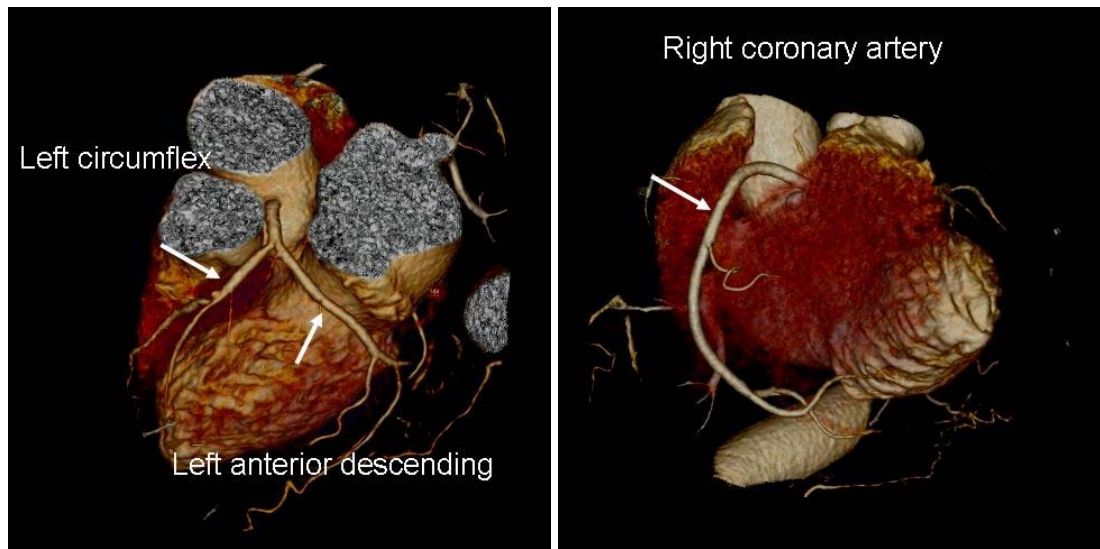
3D CT images of the heart present the left coronary artery and their side branches (left image), and the right coronary artery (right image).
